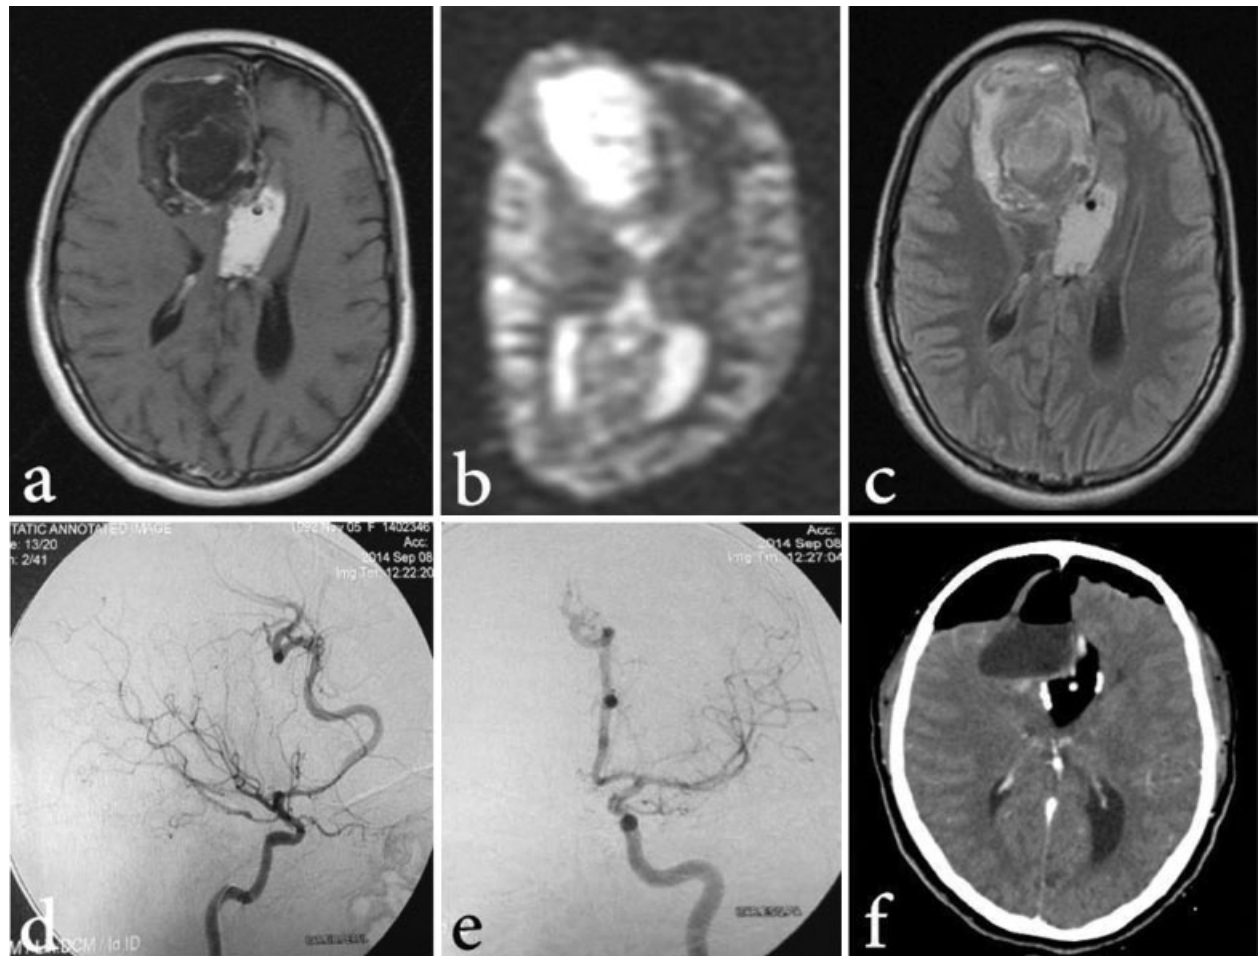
(a) T1-weighted MRI, evidencing a large heterogeneous mass in the right frontal lobe and corpus callosum, dysgenesis of corpus callosum and distortion of the ventricular system. (b) Restriction in the diffusion imaging and ADC-mapping, compatible with teratoma. (c) T2-weighted MRI, evidencing the hyperintense heterogeneous mass. (d) Lateral angiography showing hypertrophy of the anterior cerebral artery, with an azygos pattern. (e) Antero-posterior angiography confirming the azygos pattern of the anterior cerebral artery. (f) Post-operative CT scan, evidencing total resection of the solid component in the frontal lobe, and the remaining lipoma in the corpus callosum topography.
